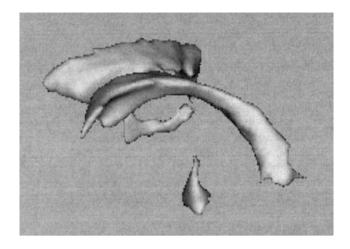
Three-dimensional reconstruction of the volumes of the lateral, third, and fourth ventricles as determined by MRI studies using the Brainmatic program.
